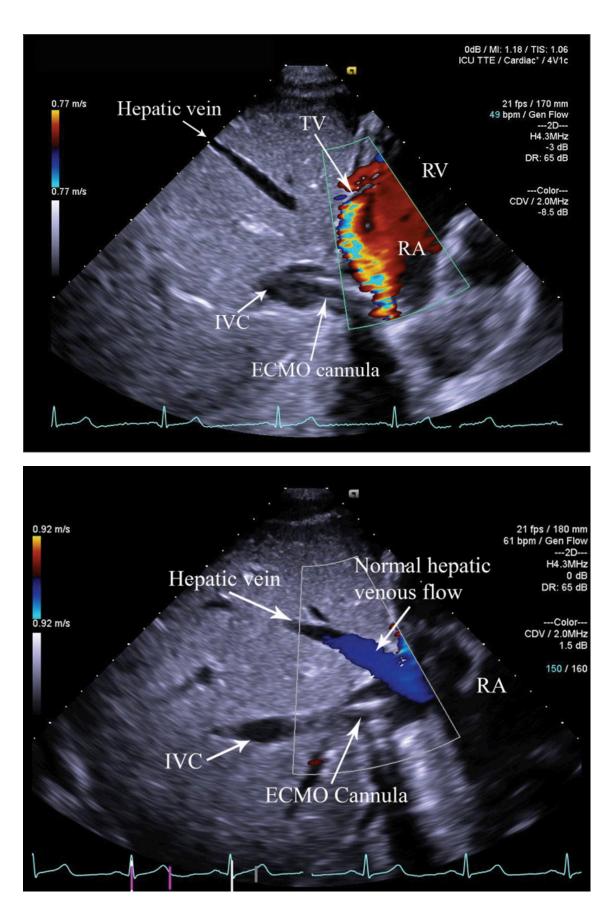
TTE Subcostal window. Long-axis IVC plane. Color Doppler interrogation of jet from the return port of VV ECMO cannula adequately positioned within right atrium and directed towards tricuspid valve postrepositioning of the cannula.
